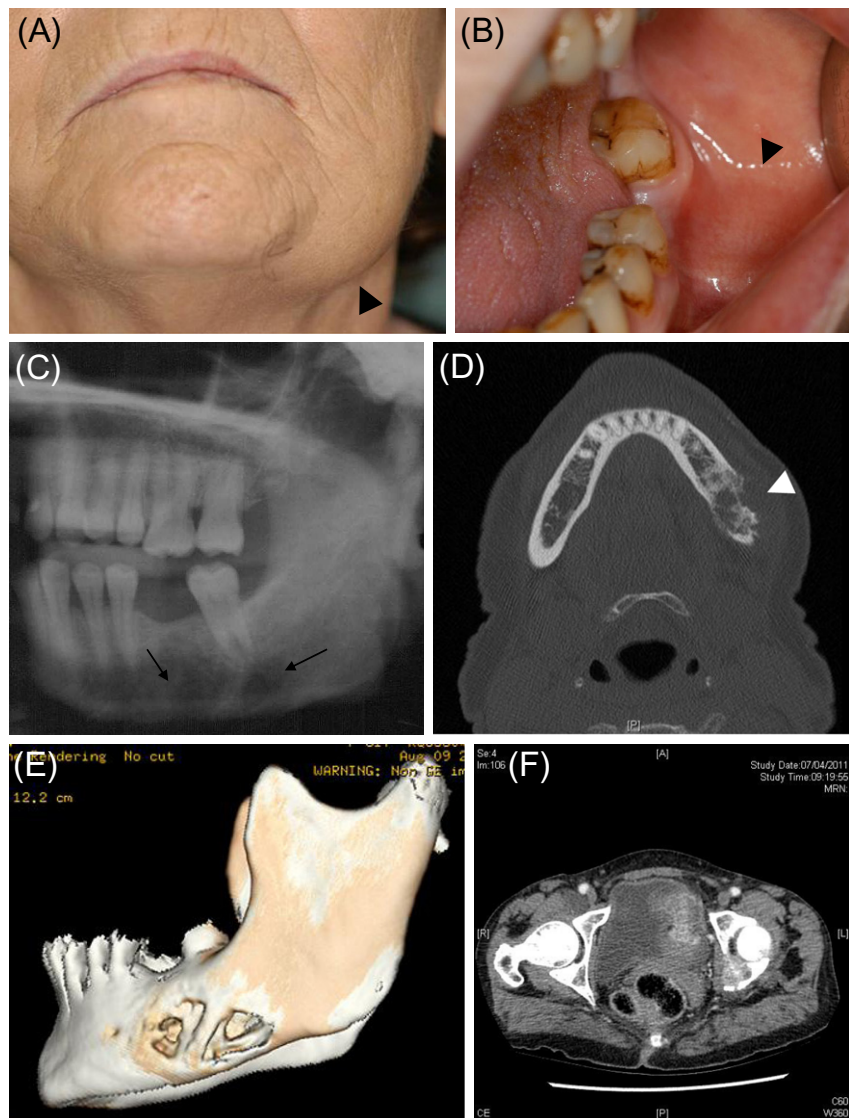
(A) Extraoral swelling (arrowhead). (B) Intraoral appearances. Shallow vestibule (arrowhead) attributable to expanded non-alveolar bone. (C) Panoramic radiograph showing a poorly defined radiolucency (arrows) centred on the left body of the mandible. (D) Conventional computerised tomography (CT) scanning shows variable destruction of cortical bone in the posterior, left mandible (arrowhead). (E) The destruction of the buccal cortical bone as appreciated on three-dimensional CT scanning. The alveolar process is not affected. (F) The abdominal CT scan image showing the ovarian mass.
